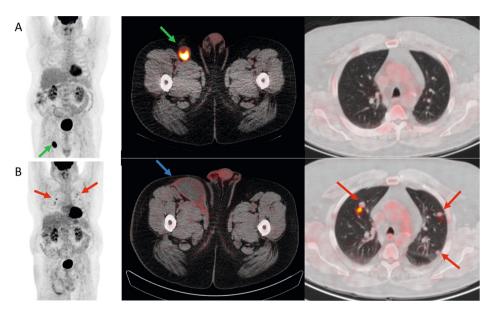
["*F]FDG PET/CT of a patient with recurrence in cohort 1: patient with previous melanoma of the right leg, presenting with stage IIIC disease. ["*F]FDG PET/CT before inguinal lymph node dissection (A) shows a lymph node metastasis in the right groin (green arrow) and no evidence of disease elsewhere in the body (maximum intensity projection of legs not shown). ["*F]FDG PET/CT 6 months after surgery (B) shows postoperative inflammation around a seroma in the right groin (blue arrow) with newly developed ["*F]FDG-avid lung metastases (red arrows).
